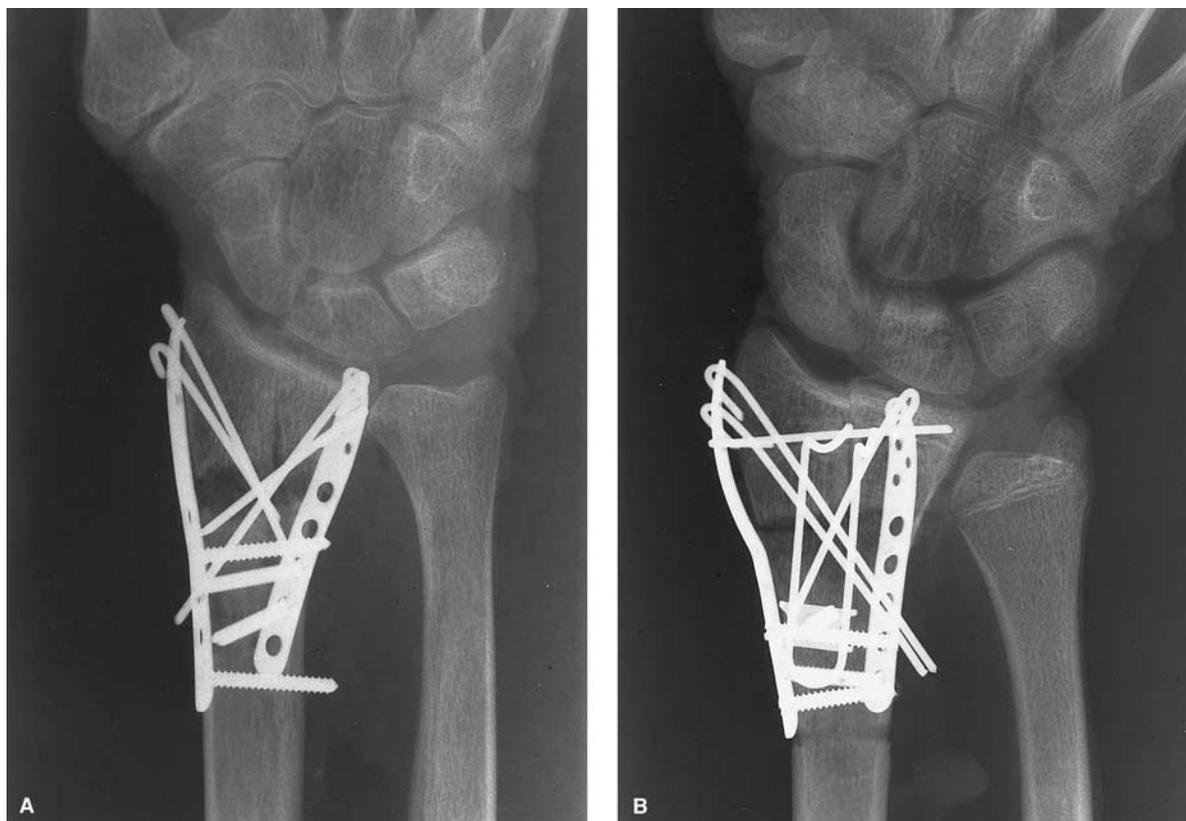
Posteroanterior-radiographs showing the fragment-specific fixation. (A) Radial styloid and ulnar pin plates used in the 3-part fracture pattern and (B) the radial styloid and ulnar pin plates along with the dorsal wire-form buttress used in the 4-part fracture pattern.
